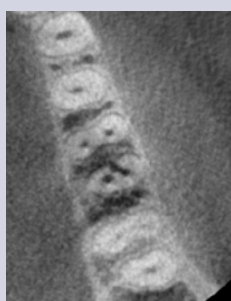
Axial CBCT slice of same tooth revealing a strip perforation of distal root at a level coronal to separated instrument.
